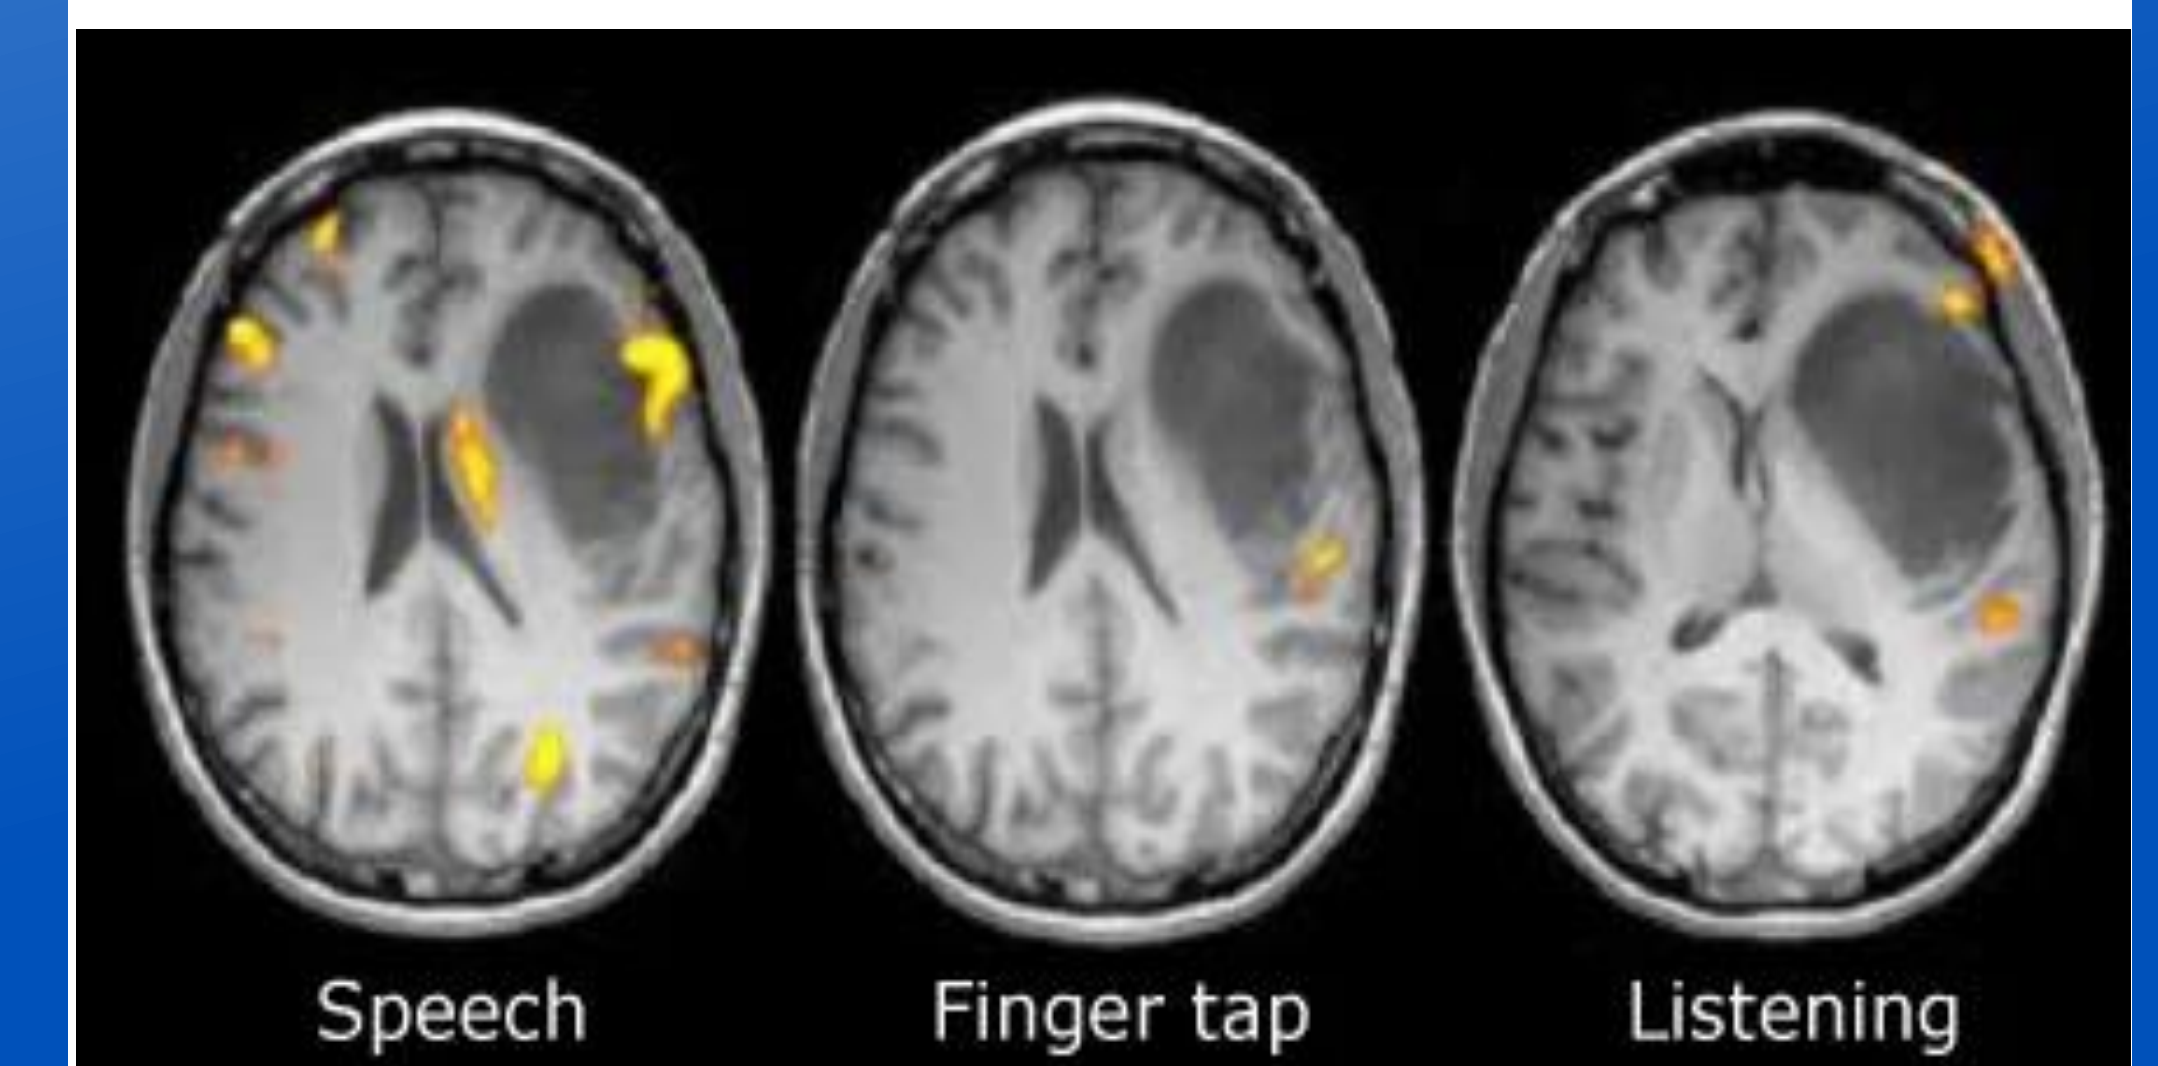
In functional MRI, brain areas “light- up” when performing certain tasks (Mayfield Clinic Staff, 2018b, para. 5)
